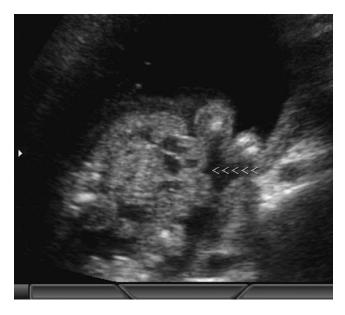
Color flow Doppler image of true thoracic ectopia cordis. This fetus was found to have severe associated intracardiac abnormalities and subsequently died in utero.
